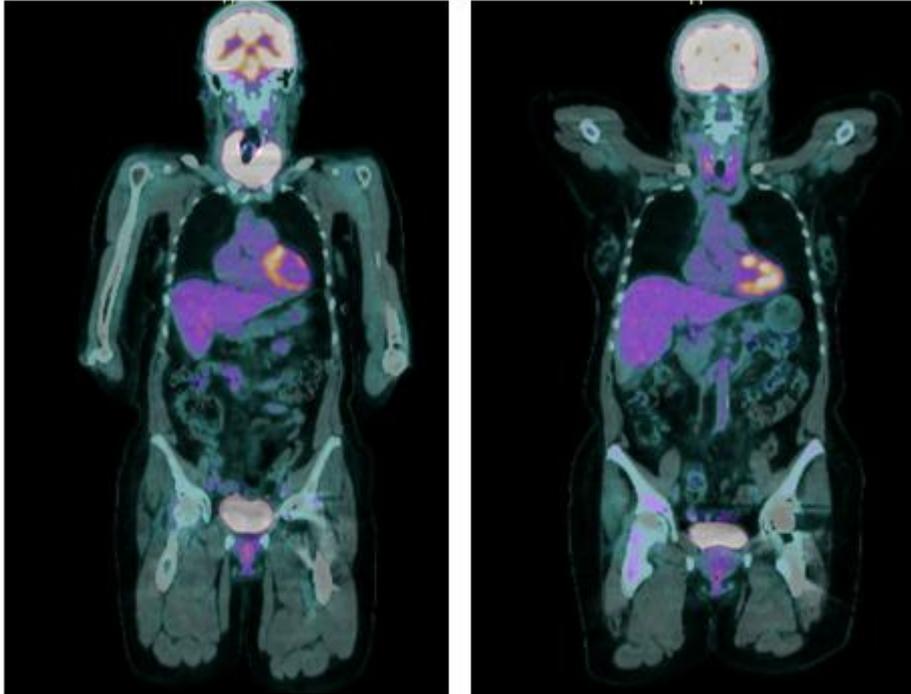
Figure 1a on the left demonstrates the initial FDG-PET at diagnosis which shows thyroid uptake and no nodal or other extra-nodal disease. Figure 1b on the right demonstrates the FDG-PET after treatment with significantly reduced FDG uptake in the thyroid and no new sites of lymphoma.
